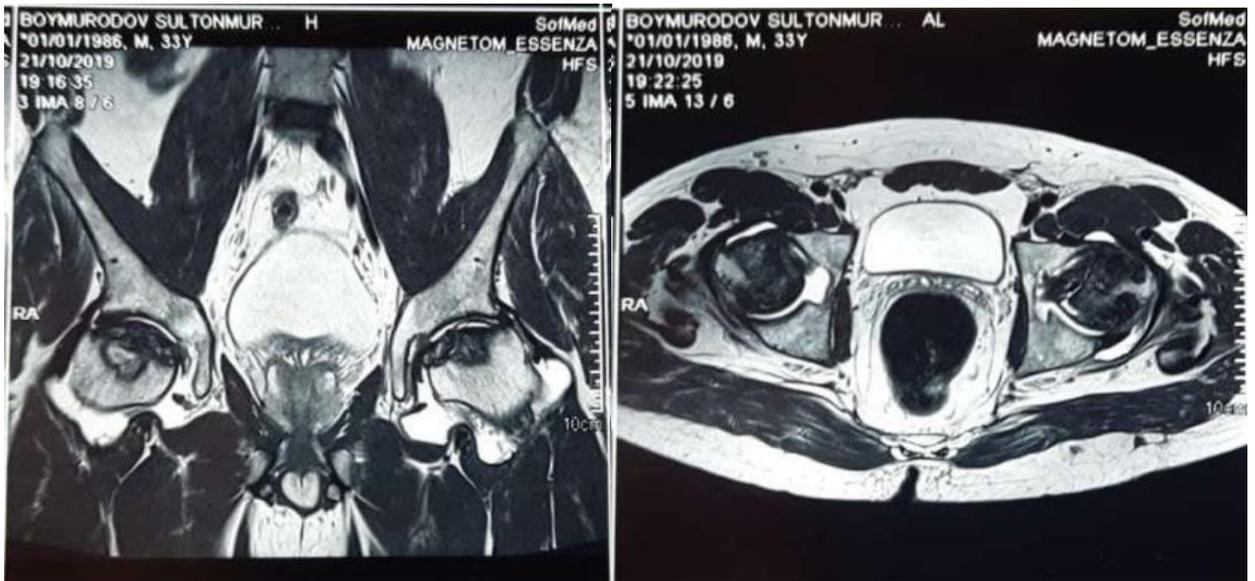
B. Patient B.S. 1986 No. IB 303/67 with ANHBK IV degrees. MRI before surgery.
